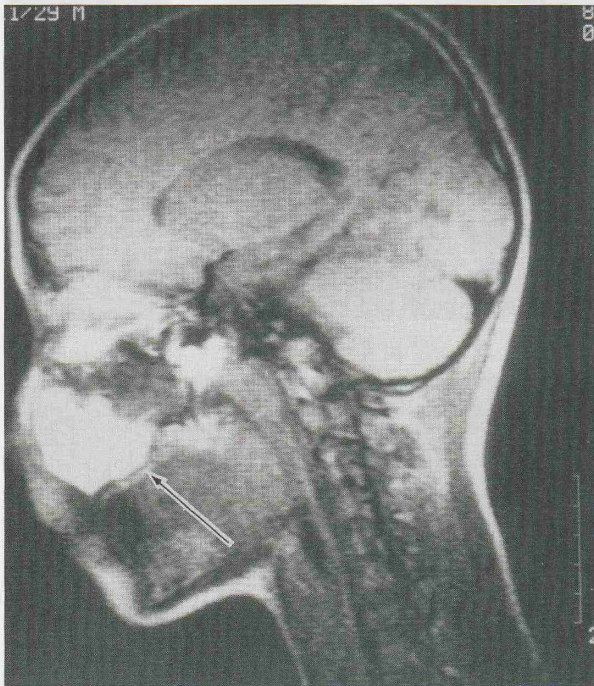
Sagittal scan of case 1 in T1-weighted MRI. A very high signal pattern with a sharp margin occupies almost all the antral space of the maxilla (arrow).
